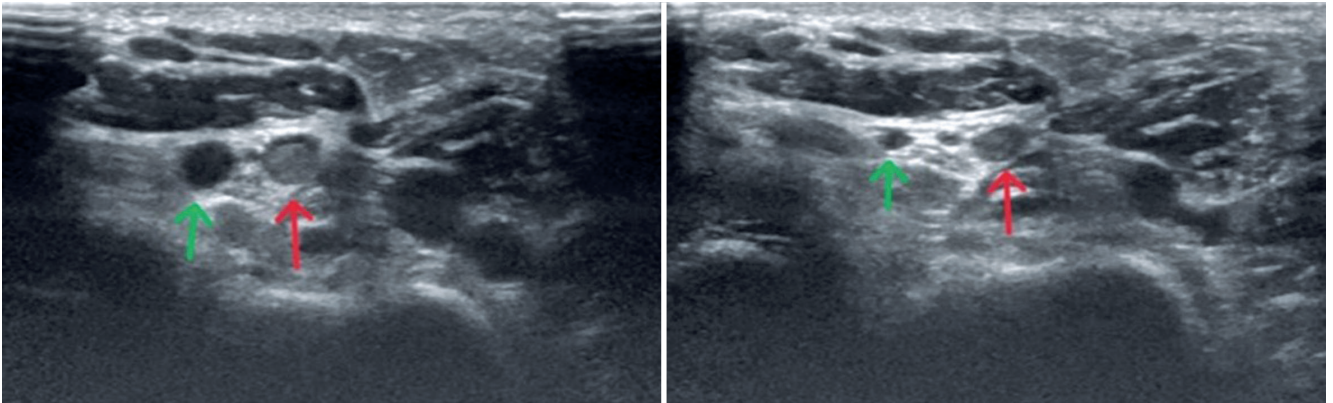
Axial gray-scale (B-mode) ultrasonographic images of the medial plantar vein pair and the centrally located artery between them. On the left, the pre-compression image shows an open lumen in the left vein and intraluminal echogenicity in the right vein, consistent with thrombus. On the right, the compression image demonstrates that the medial plantar vein on the left collapses with compression (green arrow), whereas the vein on the right remains non-compressible (red arrow), supporting the diagnosis of thrombosis.
